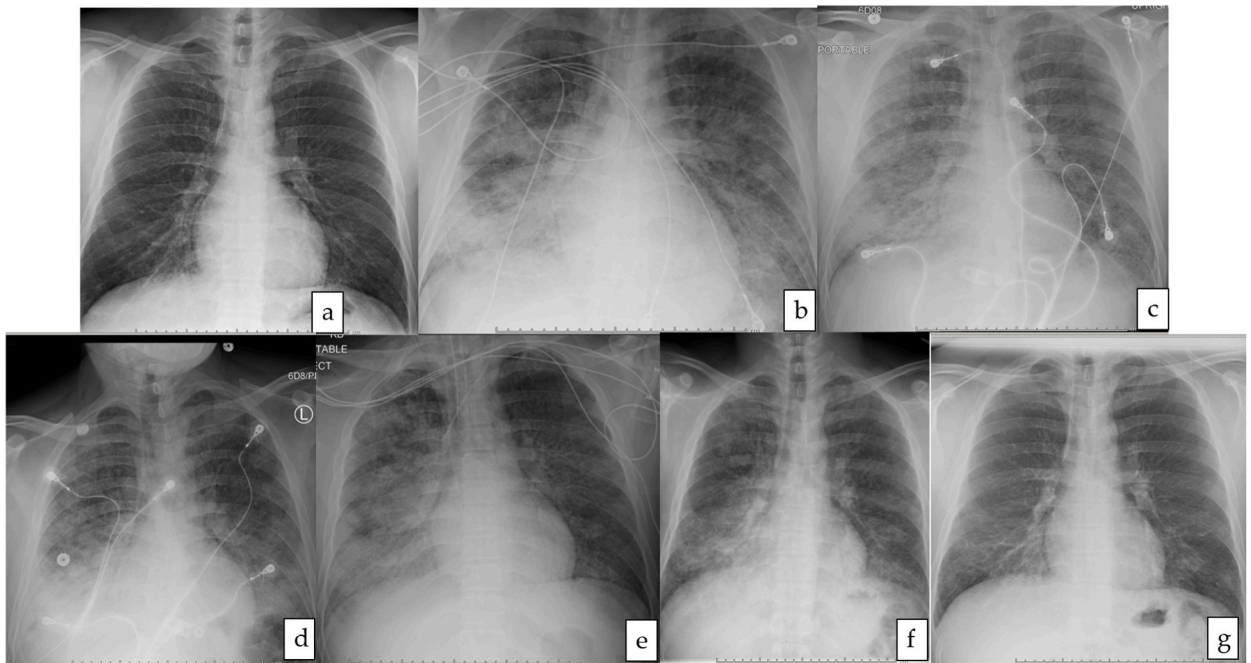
Chest x-rays before hospitalization, throughout this patient's hospital stay and after discharge shows the changes; a- April 6, 2020 x-ray for his PAP follow up which showed improved diffuse airspace opacities, b- December 6, 2020 showed multifocal airspace disease, c- December 15, 2020, no significant change compared to the 12/11/2020 chest radiograph was seen. Multifocal opacities may be due to a combination of pulmonary alveolar proteinosis and multifocal pneumonia in this reportedly Covid positive patient, d- December 19, 2020 mildly worsened findings, specifically in the right lower lobe. Bilateral multifocal opacities are likely both pulmonary alveolar proteinosis and Covid-19 pneumonia, e. December 23, 2020 after lavage shows minimally improved bilateral opacities, f-January 19, 2021 Mildly improved diffuse, bilateral reticulonodular opacities, g- March 2, 2021, Slightly improved diffuse bilateral reticulonodular opacities, April 27, 2021 showed interval improvement of diffuse bilateral reticulonodular opacities.
